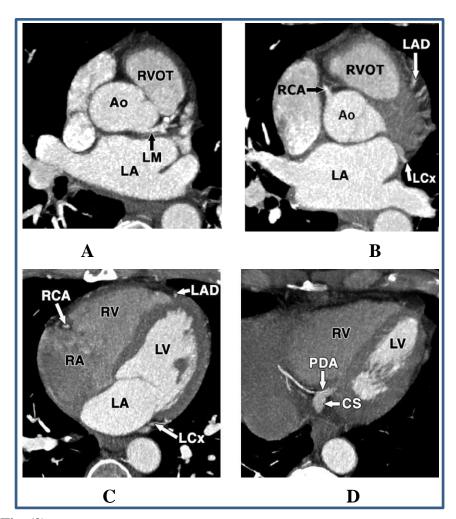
CT images of normal heart in 53-year-old man. Ao = aortic root, CS = coronary sinus, LA = left atrium, LAD = left anterior descending artery, LCx = left circumflex artery, LM = left main coronary artery, LV = left ventricle, PDA = posterior descending artery, RA = right atrium, RCA = right coronary artery, RV = right ventricle, RVOT = right ventricular outflow tract. A, Axial 5-mm maximum-intensity-projection (MIP) image shows left main coronary artery as it arises from left coronary cusp. B, Axial 5-mm MIP image shows right coronary artery as it arises from right coronary cusp inferior to level of beginning of left main coronary artery. C, Axial 5-mm MIP image shows course of right coronary artery within anterior atrioventricular groove. and Left anterior descending artery is shown within anterior interventricular groove, and left circumflex artery is shown in posterior atrioventricular groove. D, Axial 5mm MIP image shows origin of posterior descending artery from distal right coronary artery (Kini et al., 2007).
